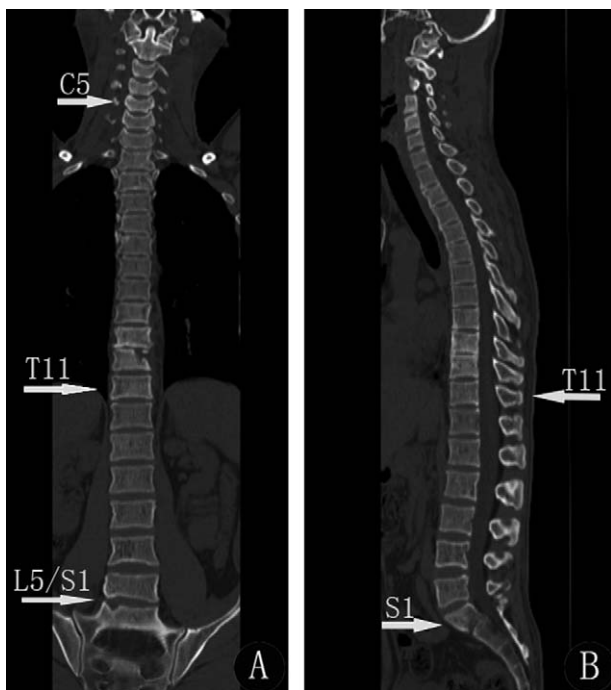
Computed tomographic images of the entire spine at 18-month follow-up. Coronal (A) and sagittal (B) showed that all the worm-eaten and osteolytic lesions of bone destruction were healed apparently including the vertebral bodies and posterior elements. And there was no evidence of recurrence.
